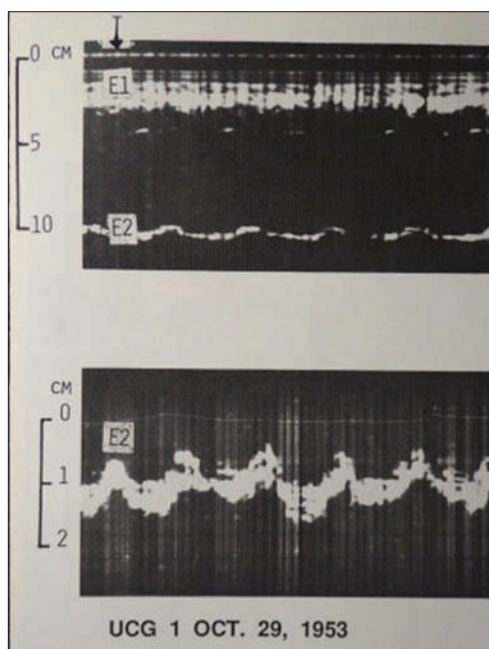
The first recorded echocardiogram from 29 October 1953. Upper panel echo from anterior chest wall (E1) to the posterior wall of the left ventricle (E2). Lower panel echo (E2) of the posterior left ventricular wall recorded at a larger scale (cm). Image from the South Swedish Society of Medical History
